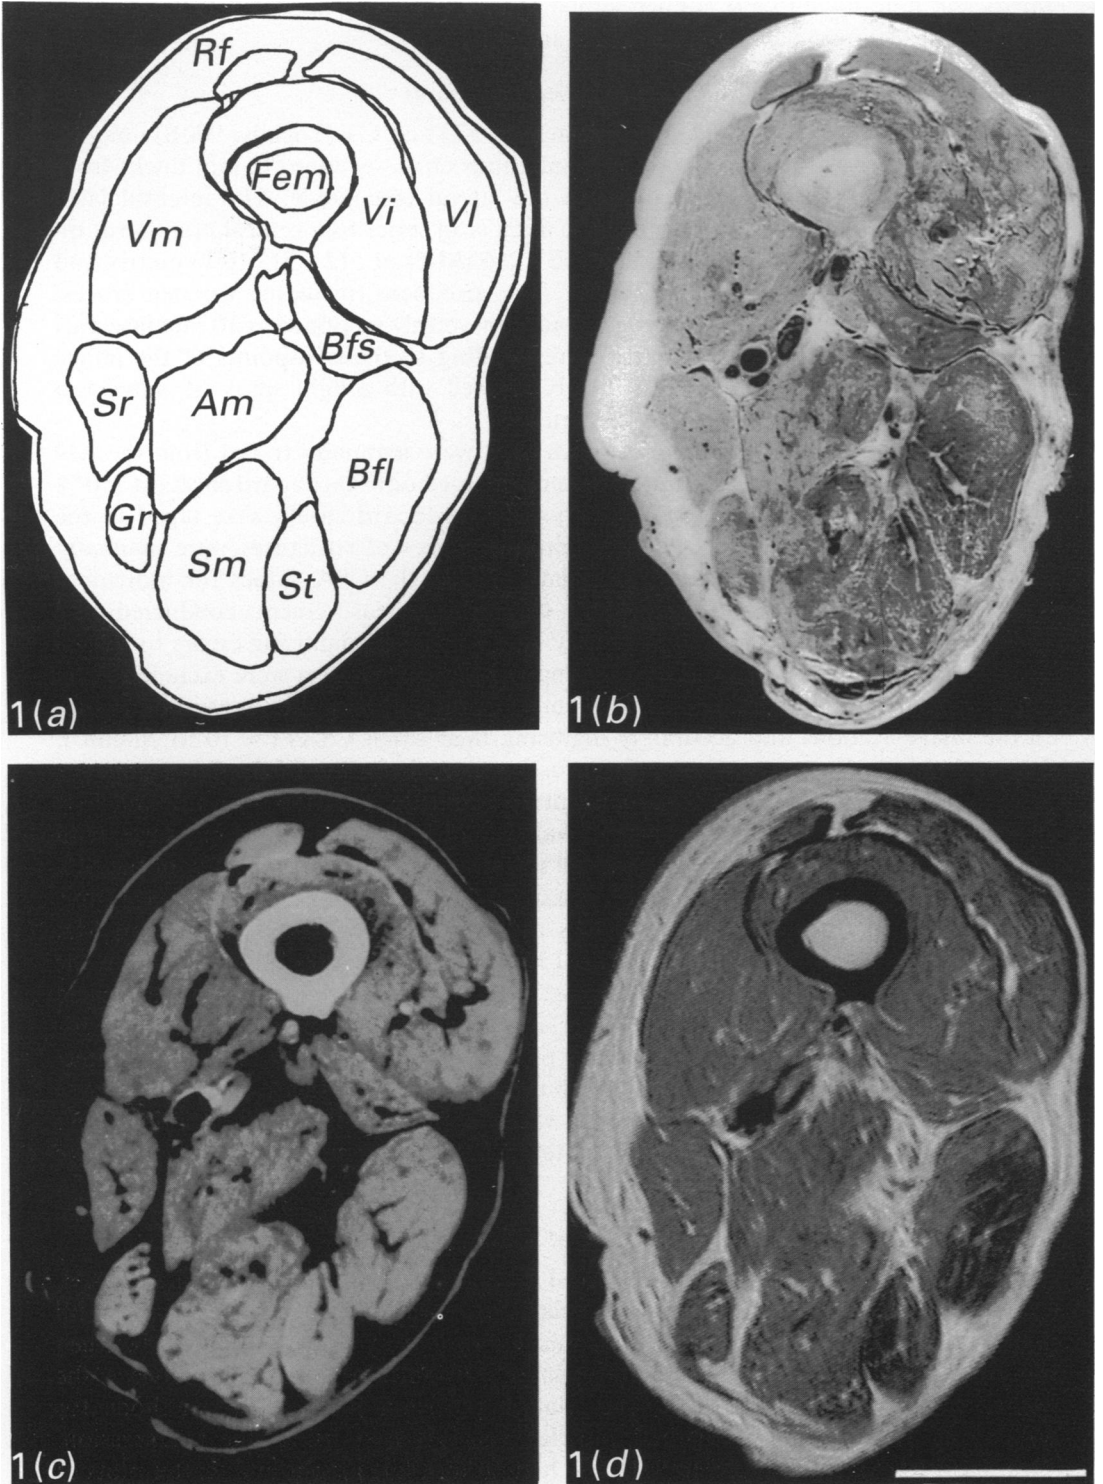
(a-d). Corresponding (a) digitised, (b) AN, (c) CT and (d) MR cross-sections from mid-thigh region (Bar, 5 cm).
